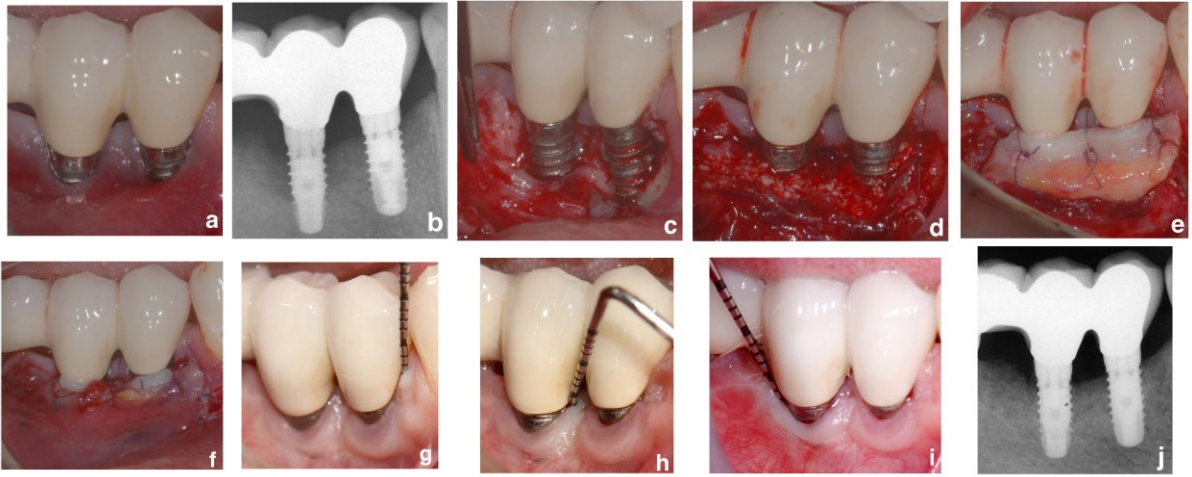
Case #3 a-b. Preoperative examination view of two implants in position #28-#29 affected by peri-implantitis. A non-keratinized, thin peri-implant mucosa associated with implant exposure is present at both implant sites. Peri-implant infrabony defect are visible on the peri-apical radiograph c. After reflection of both mucosal and periosteal layers, both implants show class Ib peri-implantitis defects. 3d-e. Infrabony component of the peri-implantitis defects grafted. Partial exposure of the xenograft coronal to the periosteal pouch is evident. A connective tissue graft (CTG) is sutured over the coronal part of the xenograft and exposed implant surface. 3f. The mucosal layer is coronally advanced, leaving the CTG partially exposed to create a band of keratinized tissue. 3g-j. Probing and radiographic assessment at 6-months.
